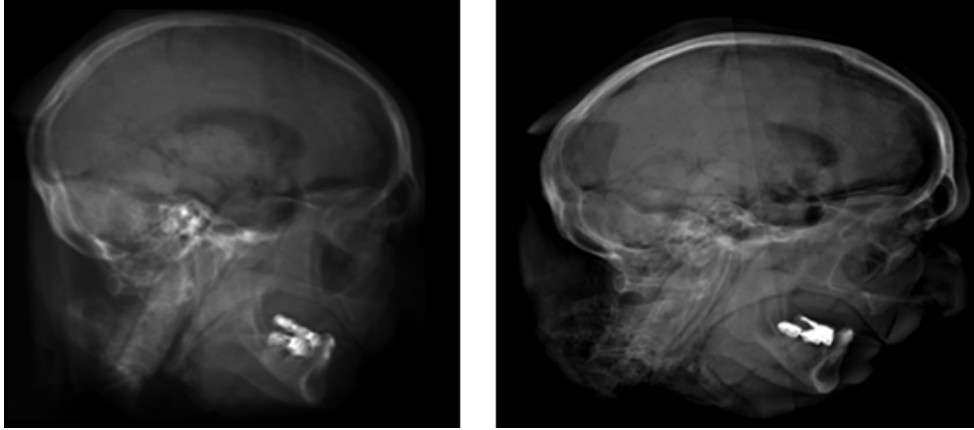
Example of a DRR (left) obtained using ray-casting through a CT volume of a patient, contrasted against an actual X-ray image of the same patient (for the Lateral view).
